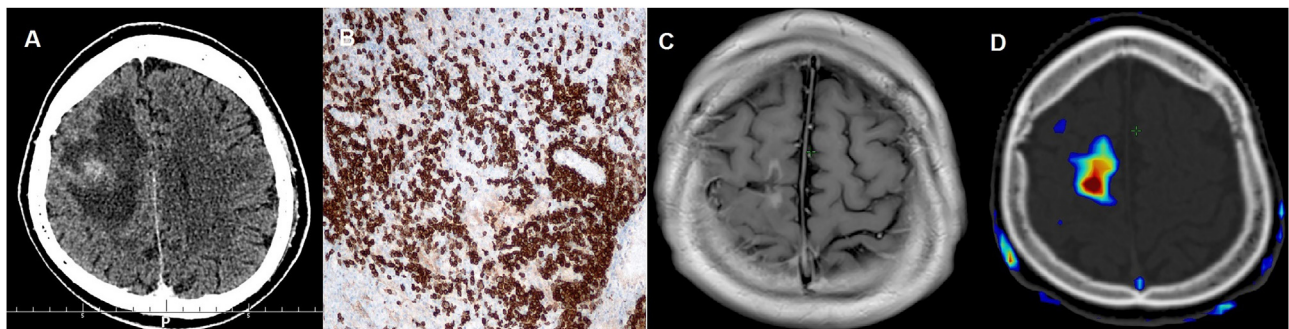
(A) CT scan showing contrast-enhanced tumor surrounded by an extensive edematous zone. (B) CD138 expression in the tumor (100 \times). (C) MRI after tumor resection showing surgical bed and irregular marginal contrast enhancement. (D) PET-CT scan showing enhanced glucose uptake at the site of tumor resection.
